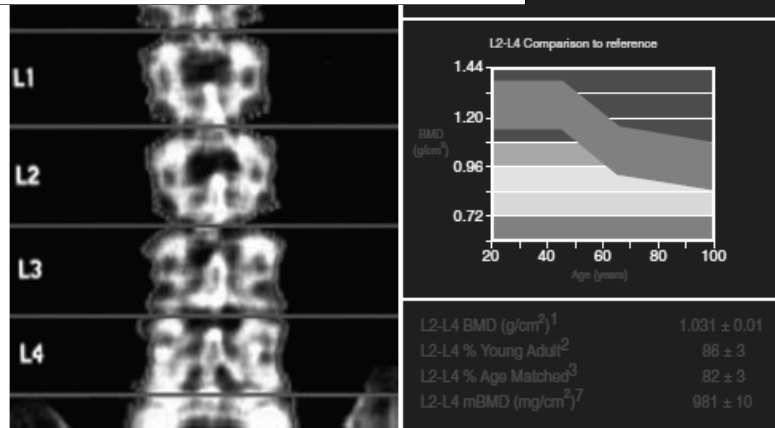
Dual energy X-ray absorptiometry of the lumbar spine. The AP image of the lumbar spine is shown on the left and on the right, the patient's value is expressed in relation to the reference range.
